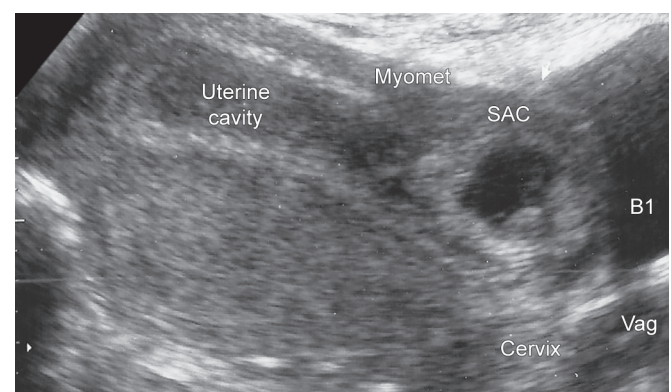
Ultrasonographic view of a scar ectopic
